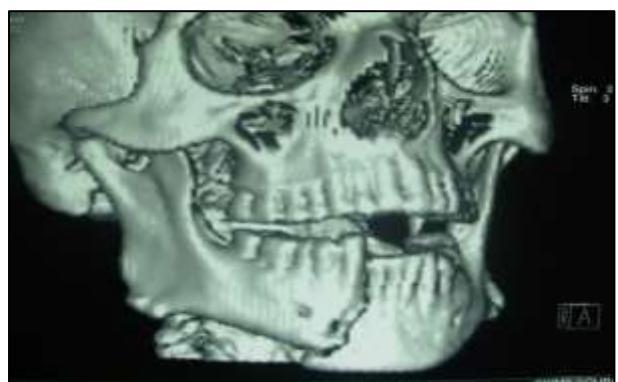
(a) CT scan 3D reconstruction showing right parasympyseal fracture mandible.
